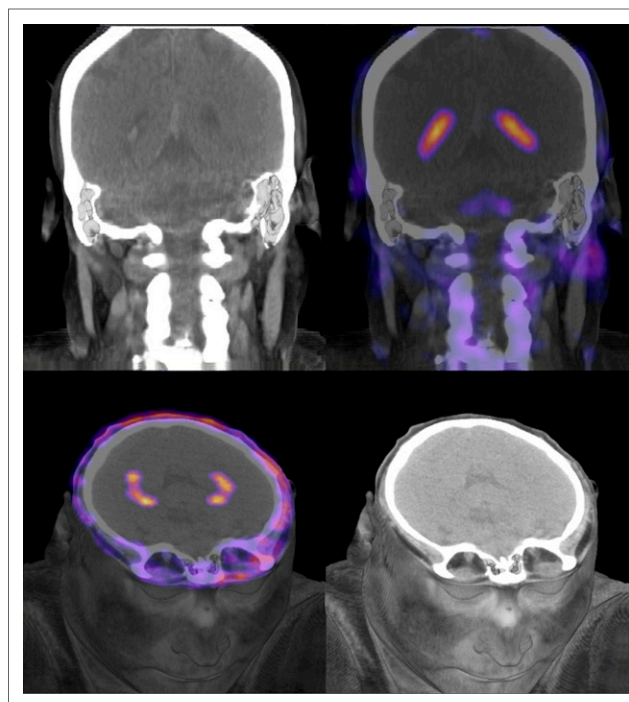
PET/CT (color) and CT (black and white) images showing normal uptake of ^{68}Ga -DOTA-E-[c(RGDfK)]₂ in choroid plexus at supratentorial ventricular system.
